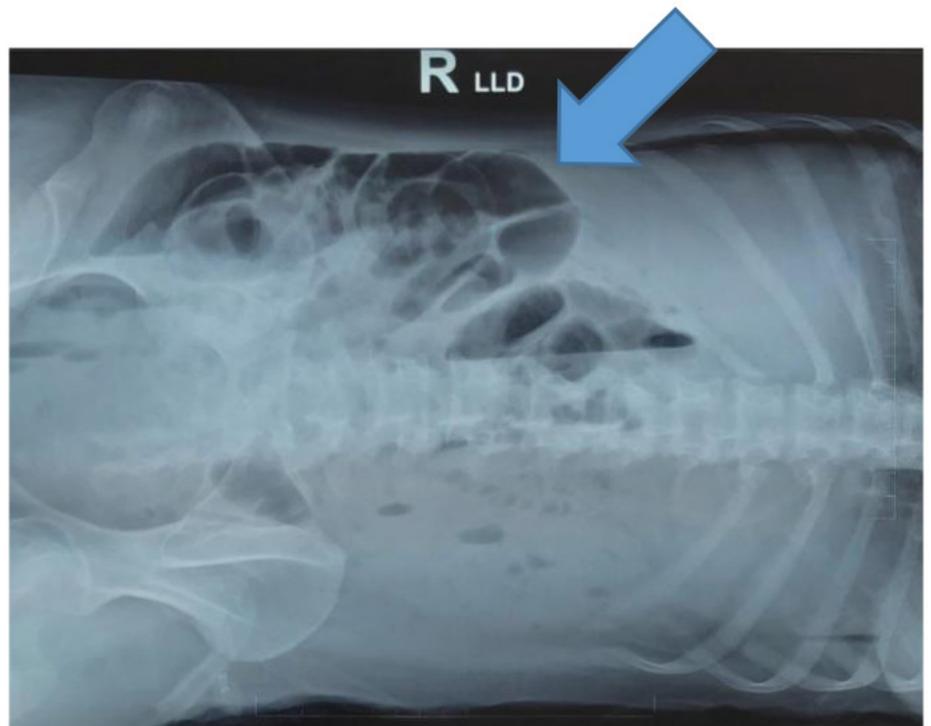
Plain abdominal radiograph in LLD position showed pneumoperitoneum
